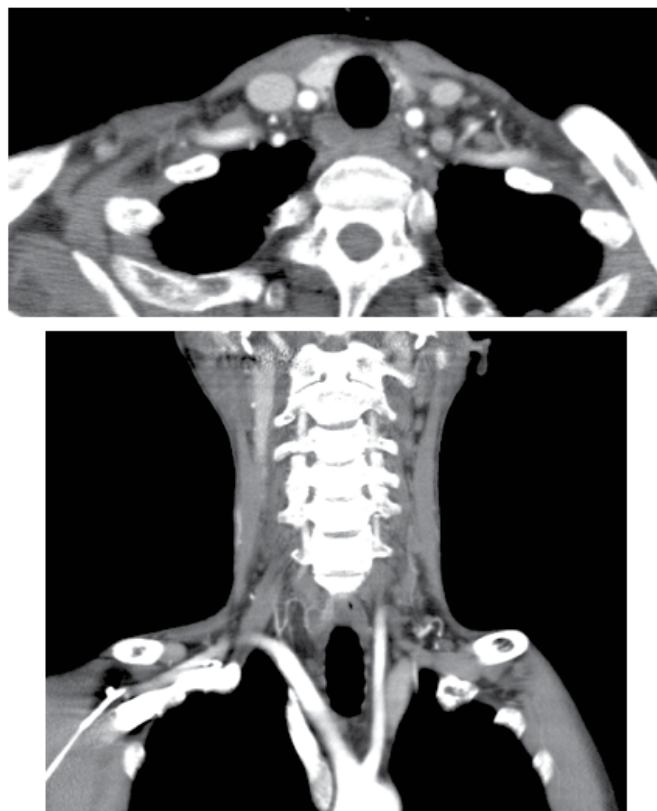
Computed tomography of neck showing a hypodense mass in the right side of the neck with peripherally enhancing walls measuring approximately 3.0 × 2.0 cm.
